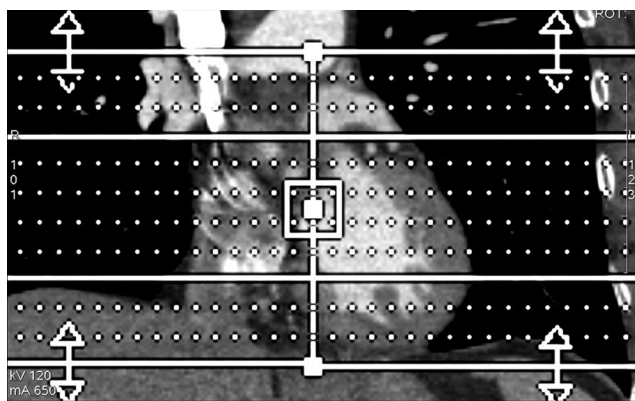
Coronal CT image of the chest showing batch horizontal lines covering the heart from the left atrial appendage to the diaphragm.
